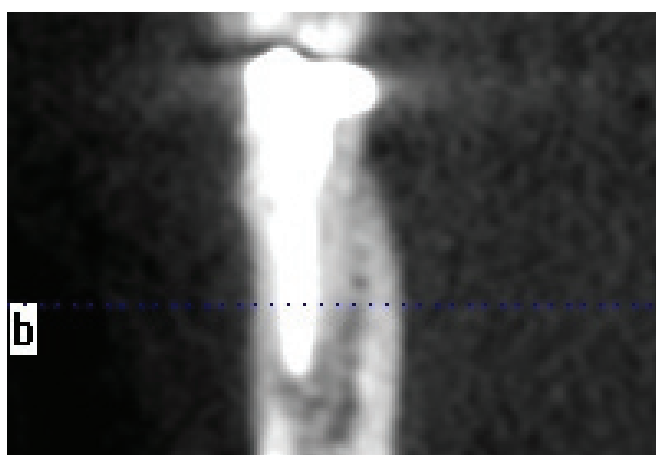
Post-operative Cone beam computed tomography (CBCT) at 6-month interval.
